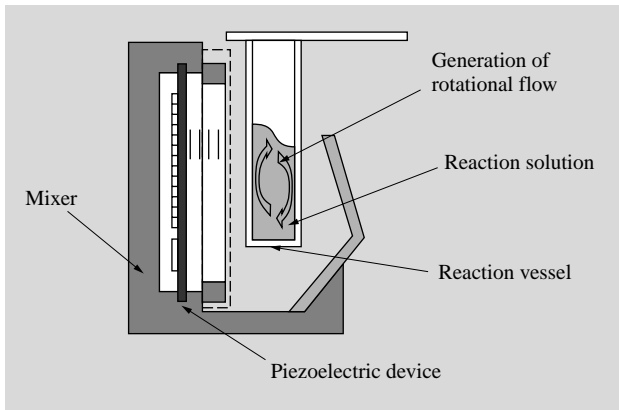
Ultrasonic Mixer.⁽⁴⁾
